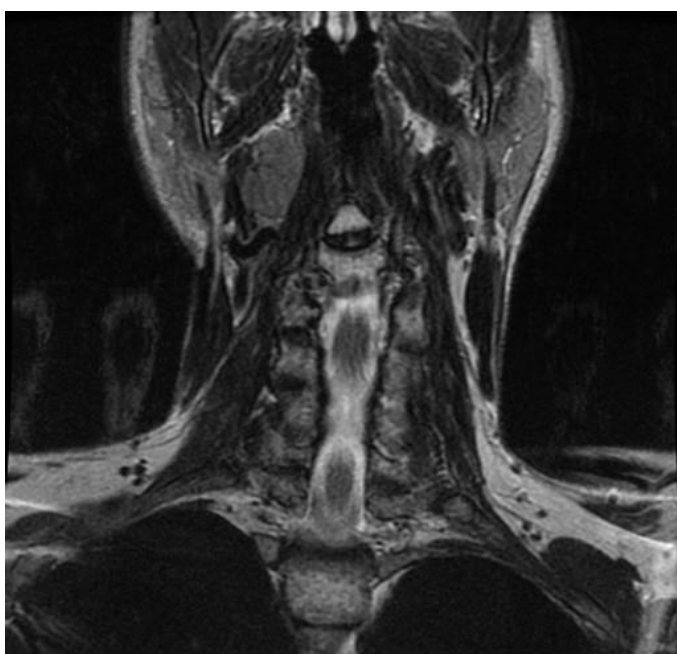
Metastasis of the medullary thyroid carcinoma into the parapharyngeal space as visualized in cervical MRI scan.
